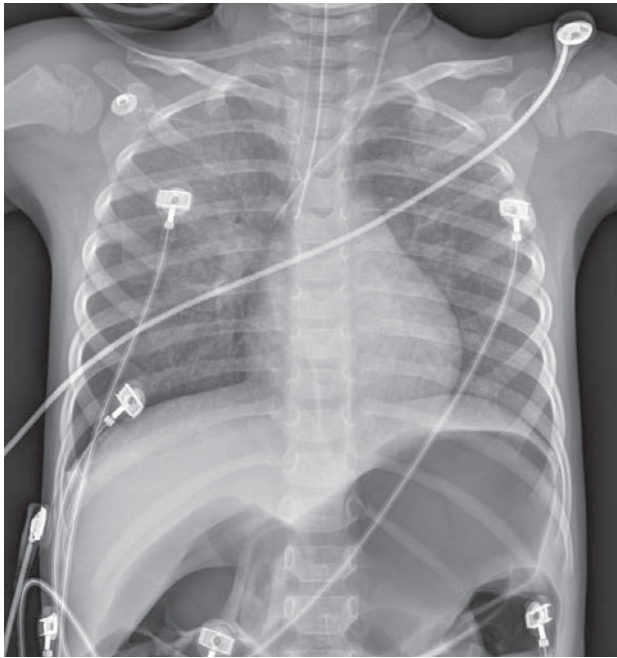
On January 20, 2013 at 15:21, a chest x-ray AP supine position reveals early pulmonary edema. Heart appeared normal. The tip of the catheter was in SVC, endobroncheal tube is in place.
